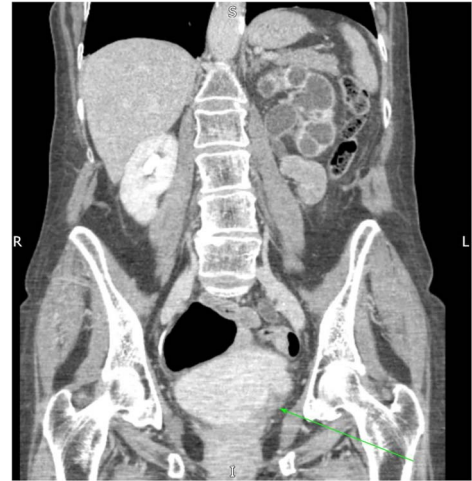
CT identifying left-sided mural bladder mass (arrow) and left-sided hydronephrosis.
